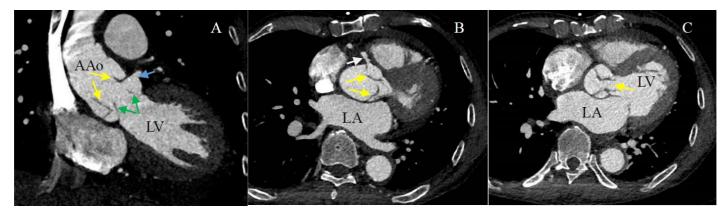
The aortic CTA showed views of the Stanford Type A₃ aortic dissection with proximal intima intussusception (A: coronal during systole, B-C: axial during diastole). Yellow arrow: intimal intussusception. Green arrow: aortic valve leaflet. Blue and White arrow: left and right coronary artery ostia respectively. AAo: ascending aorta; LV: left ventricle; LA: left atrium.
